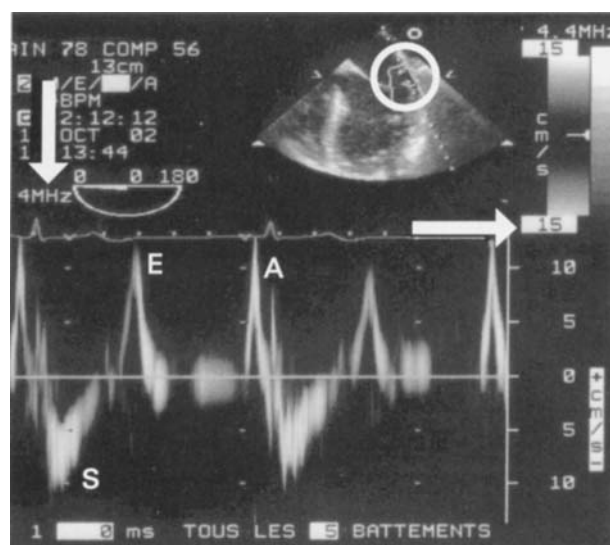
Pulsed wave tissue Doppler of the mitral ring. The transducer is in the lower range of frequency (vertical arrow), the maximal velocity is set at 15 cm/s (horizontal arrow), and the sampling volume is 0.5 cm (circle). The systolic descent (S) of the mitral ring is visible in systole, whereas two components (E and A) appear in diastole. The direction is opposite to the direction of blood flow; with the transoesophageal probe the systolic motion is away from the transducer, whereas the diastolic components move toward the transducer.
